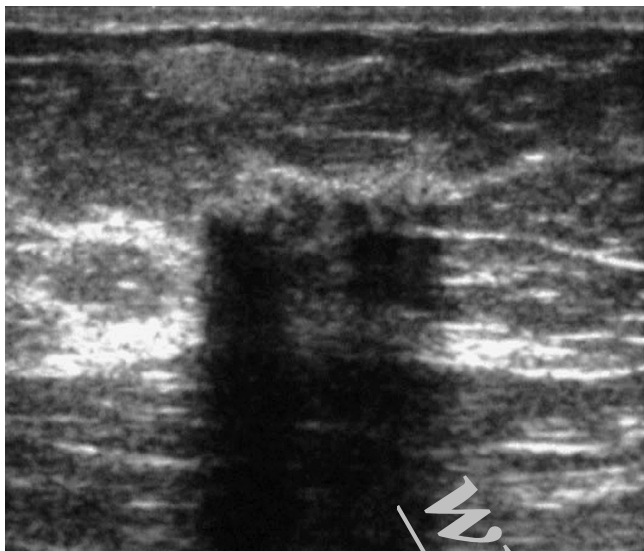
Ultrasound Visible Biopsy Marker. An ultrasound image of breast tissue containing gel pellets placed at the site of a stereotactic biopsy showing how the mass effect with distal shadowing allows the biopsy site to be easily identified on ultrasound.
